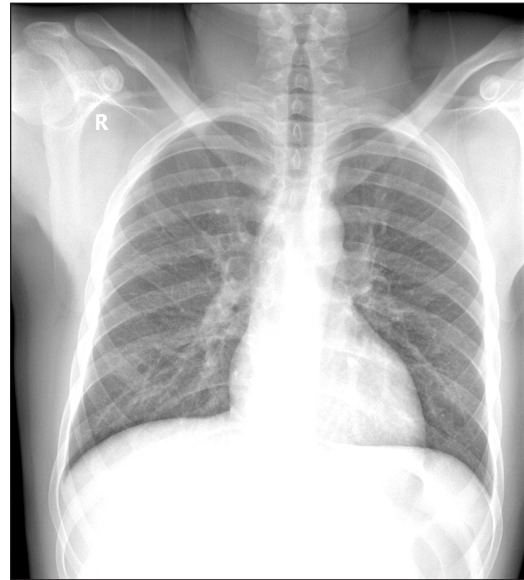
Bilateral parahilar peribronchial infiltrates were recorded in chest X-ray.
